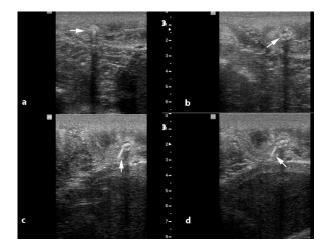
Ultrasonographic appearance of cytobrushes (arrows) embedded into the uterine wall.
